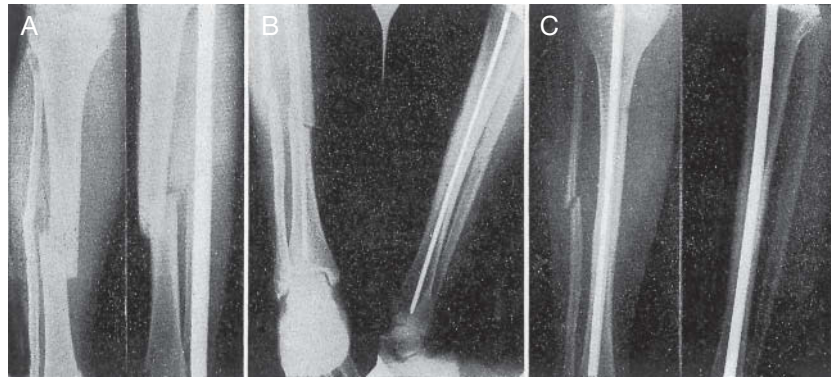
A.F.F. Closed transverse middle-third fracture of tibia and fibula. A: Preoperative x-rays. B: Perioperative x-rays with the guide in place. C: Radiographic image showing full healing at 1 month from surgery. In this case, the patient was allowed to walk with cast immobilization at 15 days. The cast was removed at 1 month.
